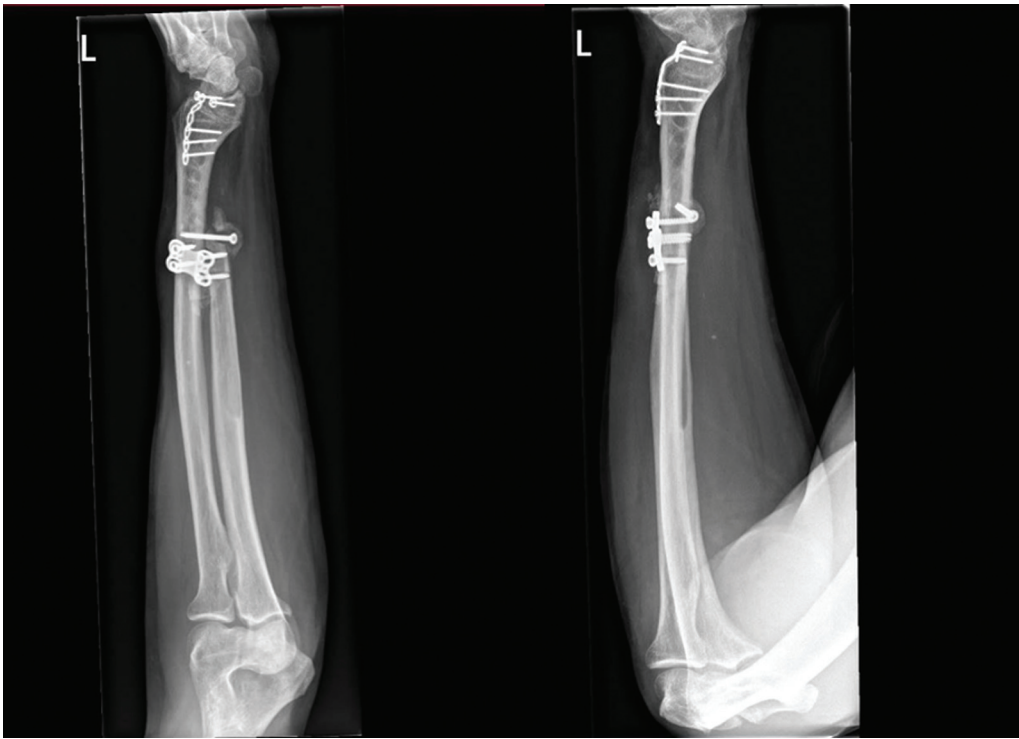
Anteroposterior and lateral X-rays of Case 3, 2, 5 months after one bone forearm procedure. Note, the non-union.
